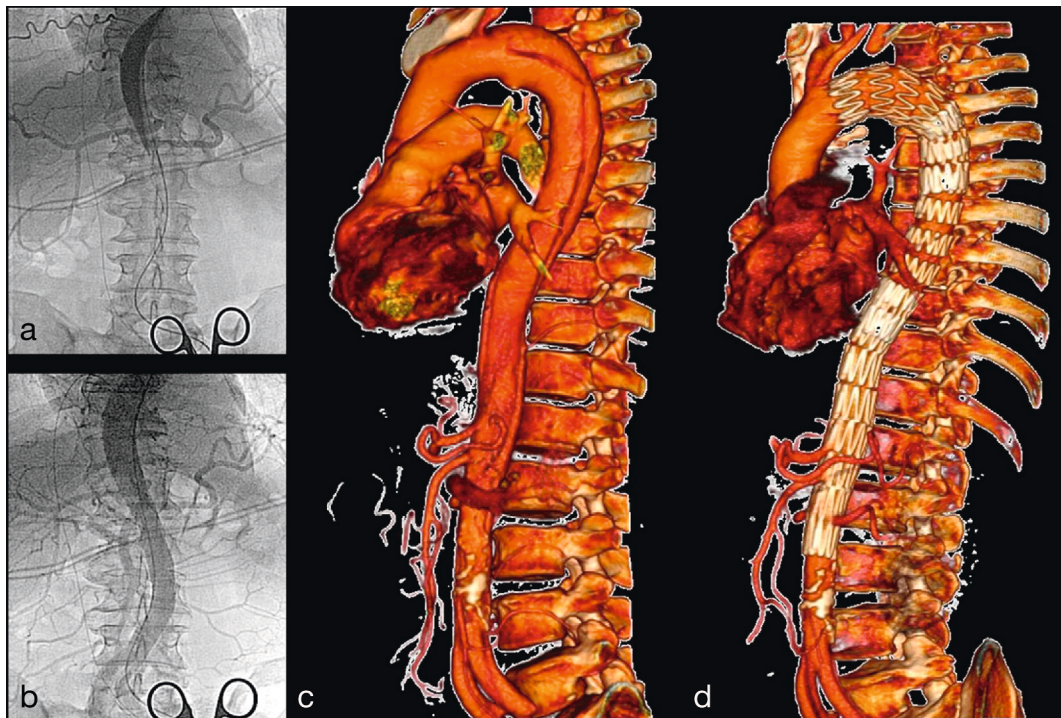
Malperfusion syndrome treated with an endovascular stent-graft and PETTICOAT. (a) Angiography of lower body malperfusion; (b) reperfusion after a proximal stent-graft insertion; (c) 3D CT reconstruction of an acute complicated dissection with malperfusion; and (d) a reconstructed aorta and abolished malperfusion after stent-graft and PETTICOAT treatment. Reproduced from Nienaber CA, Kische S, Ince H, Fattori R. Thoracic endovascular aneurysm repair for complicated type B aortic dissection. *J Vasc Surg* 2011; 54(5): 1529–1533 with permission.
